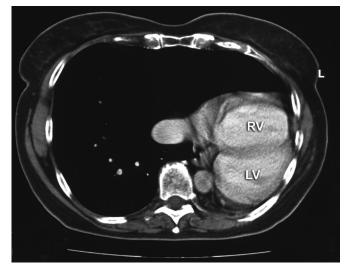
The patient's axial computed tomographic image. Notice that the left ventricle is repositioned and placed against the left dorsal chest wall. L, left side of patient; LV, left ventricle; RV, right ventricle.
